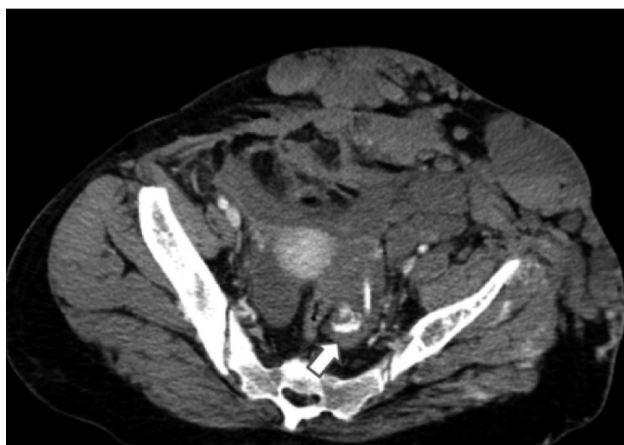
Abdominal computed tomography scan (arrow indicates active contrast leakage in the right ovary and in the left pelvic cavity).
